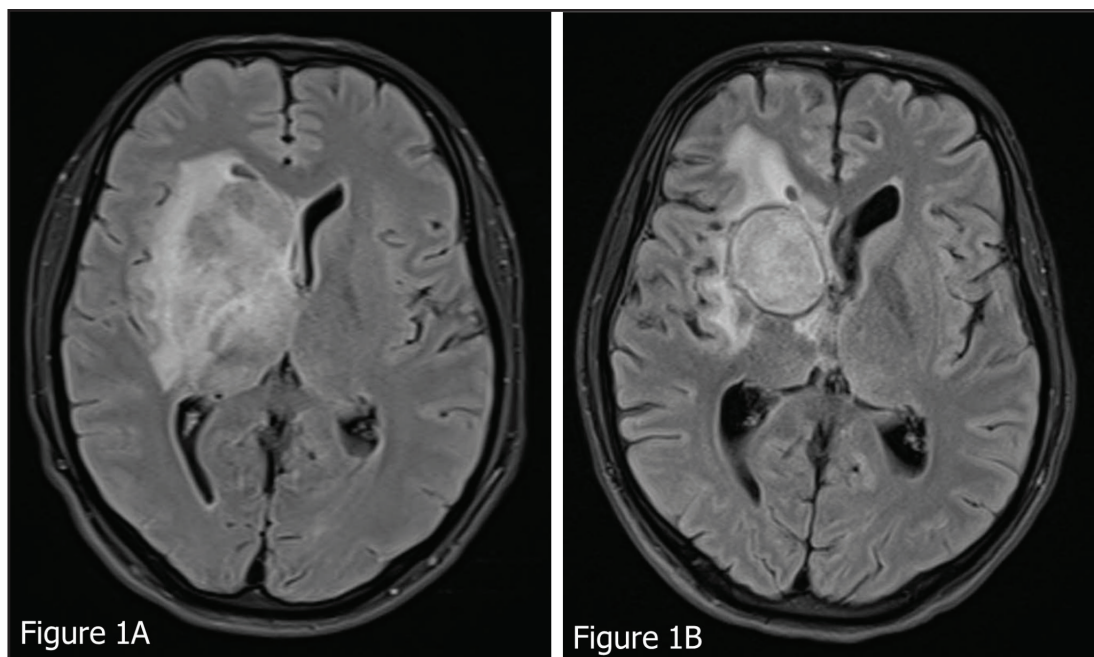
A: T1-weighted axial view of MRI demonstrating an enhancing right basal ganglia mass measuring $4.4 \times 4.3 \times 5.1$ cm, extending into the right thalamus and right temporal lobe, with mild leftward midline shift. B: T1-weighted axial view of MRI at 16 weeks post-treatment showing reduction in the right basal ganglia mass to ($4.0 \times 2.9 \times 3.0$ cm), with decreased peri-lesional edema and improved midline shift.
